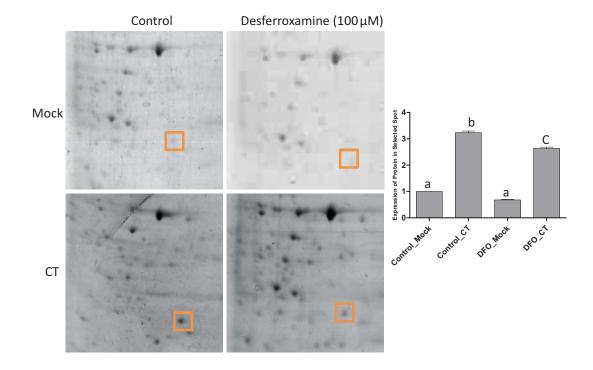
Secretory protein profile of CT infected and DFO treated CT infected cells:
